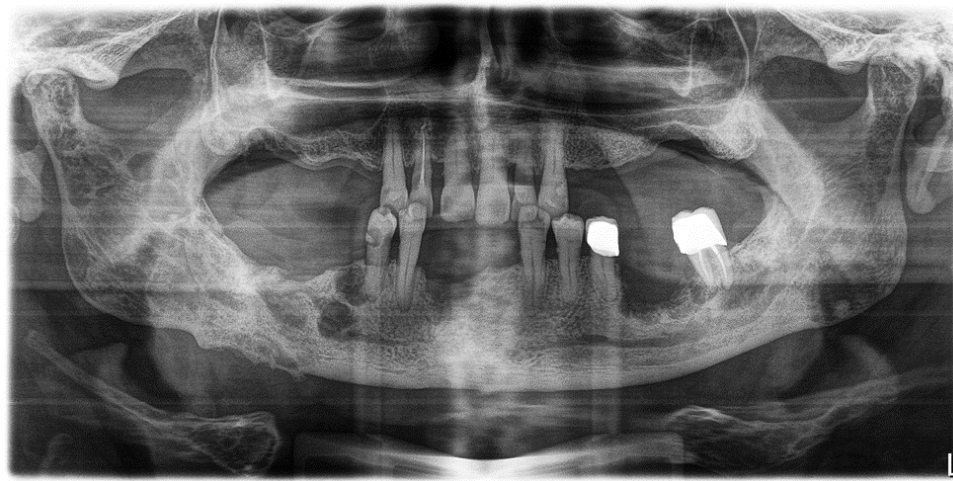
Panoramic X-ray 12.2022
